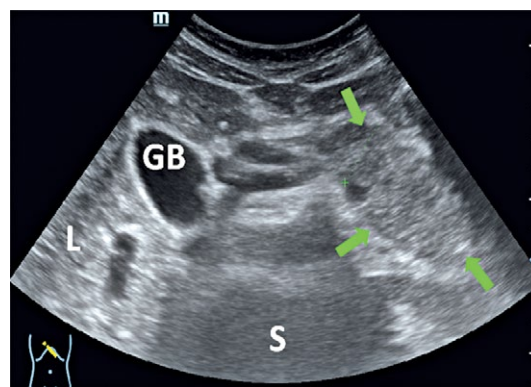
Transabdominal ultrasonography one day after rechallenge with 5-ASA (06.08.2017): the pancreas (marked with arrows) is slightly inhomogeneous with low echogenicity, consistent with acute inflammation. L=liver, GB=gall bladder, S=spine.
